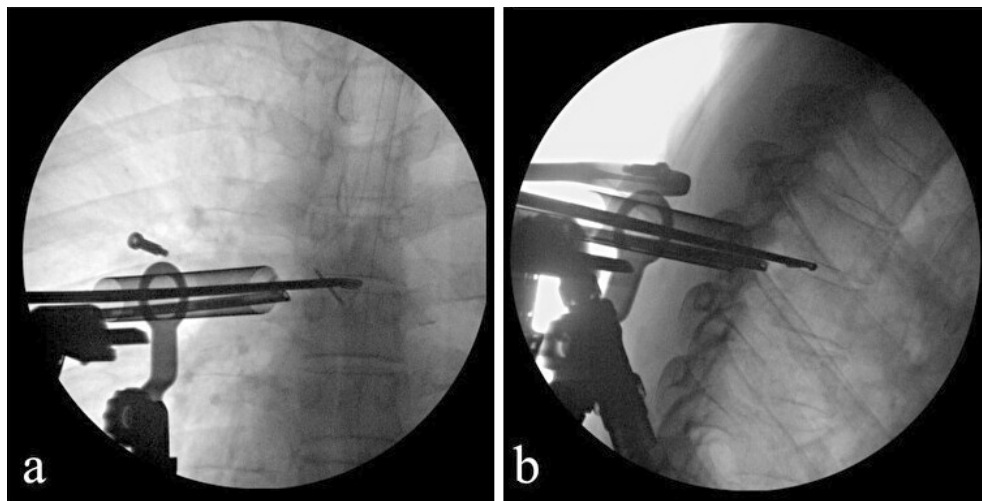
Radiographs of the frontal (a) and lateral (b) view by the C-arm show that the micro-rongeur is inserted in the proper position to remove the central herniation.
